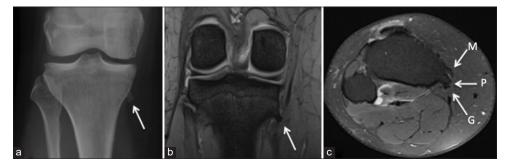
Anterior-posterior radiograph (a) and STIR coronal (b) and axial (c) showing the pes anserine exostosis (arrow) (P) between the tibial component of the superficial medial collateral ligament (M) and gracilis (G).
